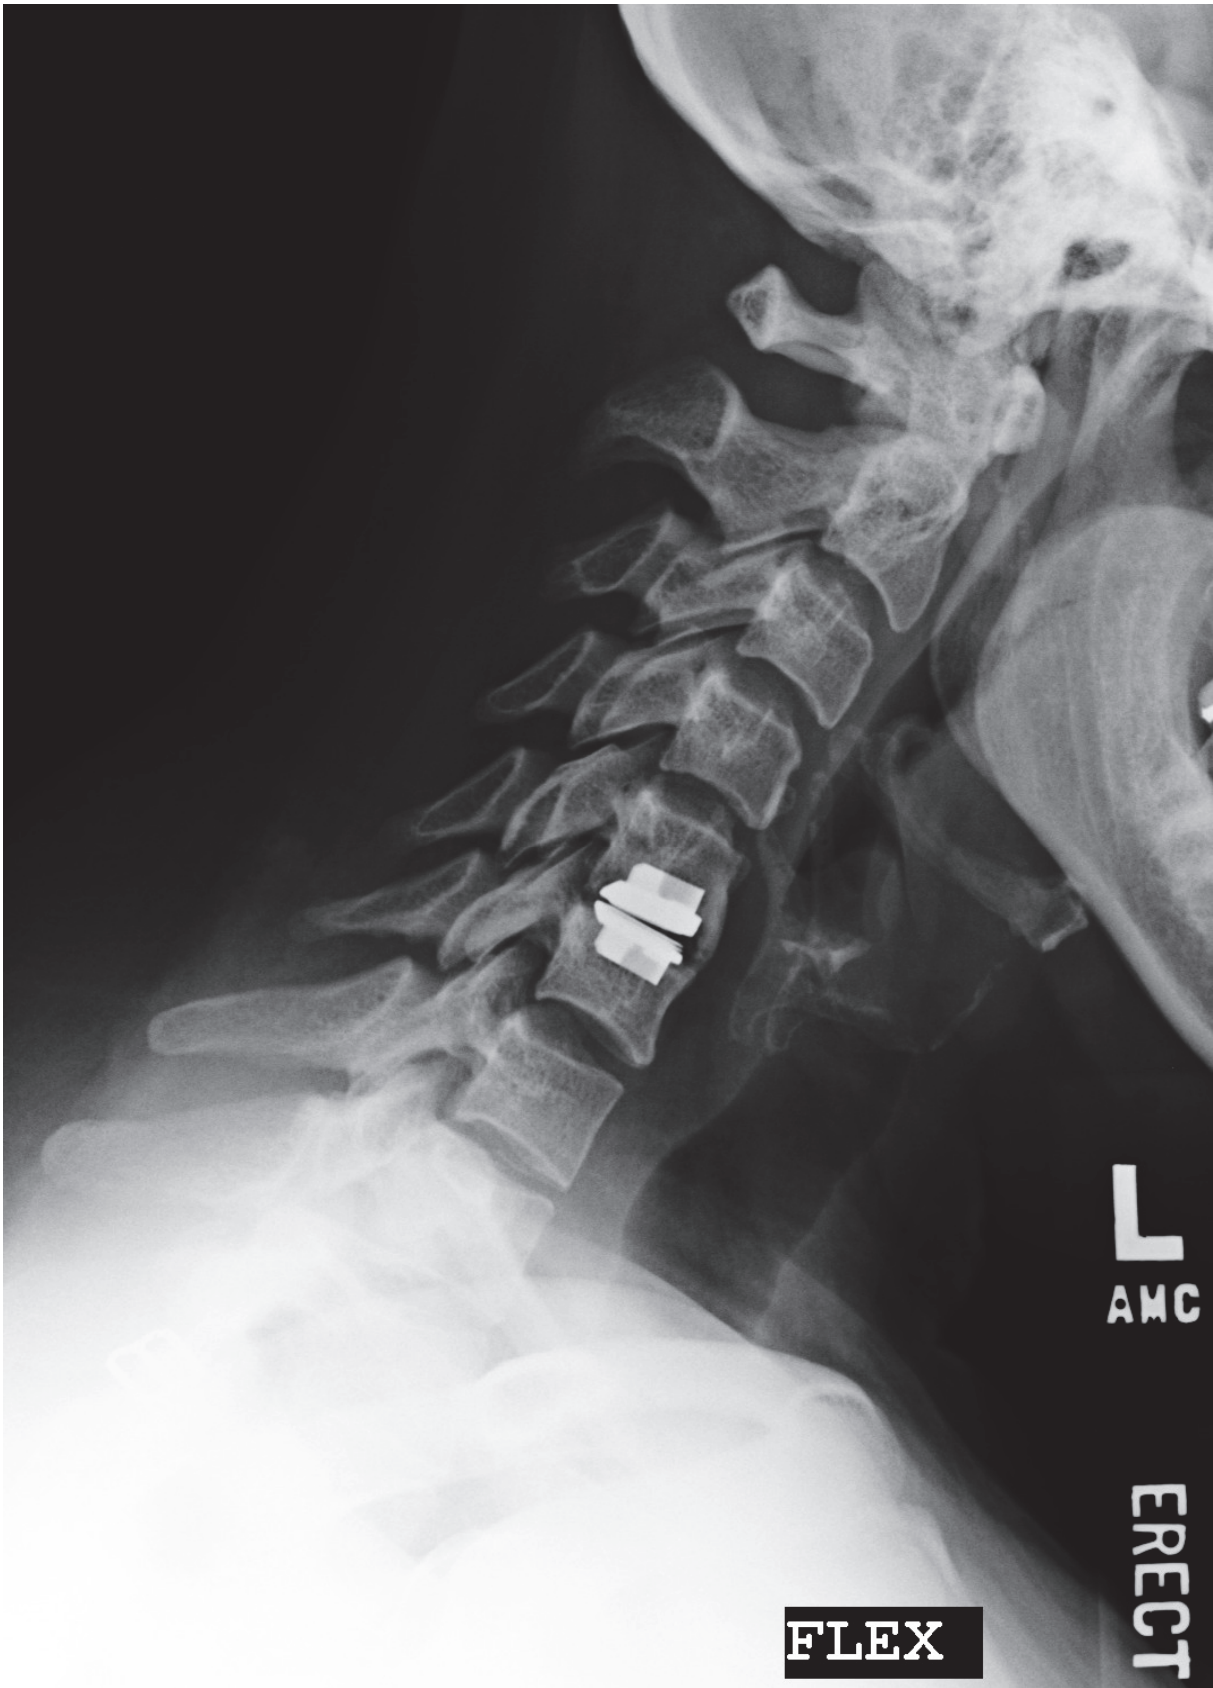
Lateral flexion radiography- implanted ProDisc-C with heterotopic ossification, preserved motion.
